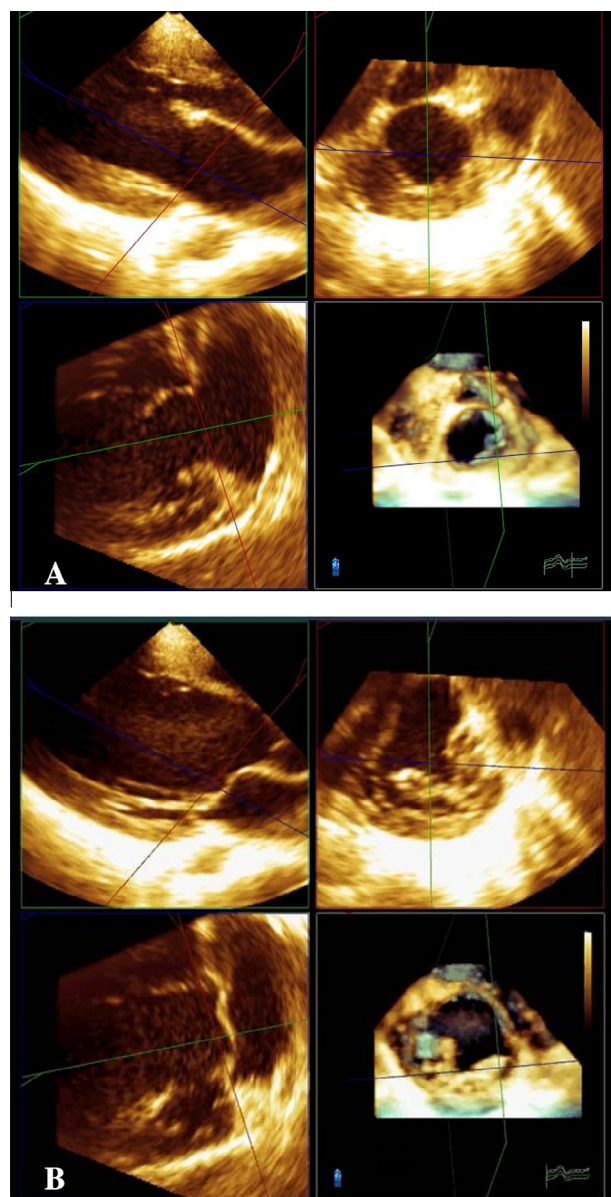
Multiplanar reformatting (MPR) technique used to detect even trivial Mitral valve prolapse (MVP) demonstrating three colour-coded boxes with 4th box in the right lower quadrant showing full volume three-dimensional echocardiography (3DE) dataset. (A) In diastolic phase putting actual physical line along the hinge points of the MV in the blue box (left lower quadrant box) and in the green box (left upper quadrant box) demonstrating no MV tissue in the left atrium (LA) in the red box (right upper quadrant box). (B) during systole; with MV closure, MV tissue started to appear in the left atrium (LA) in the red box (right upper quadrant) confirming the MVP. Note that since the red colour-coded bar was placed in the blue and green boxes, the changes are traced in the corresponding colour-coded box, which is the red box here.
